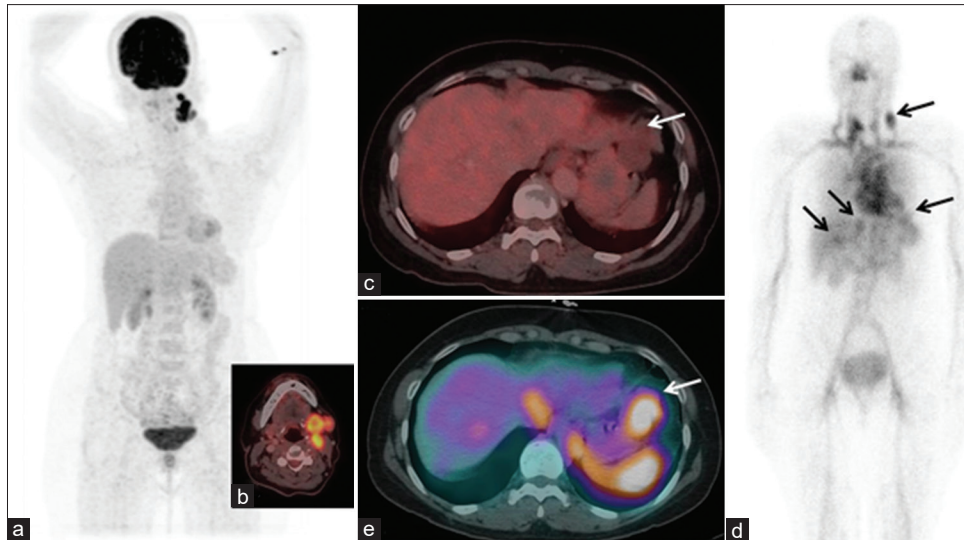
Staging F-18 fluorodeoxyglucose (FDG) PET/CT MIP image a) revealed hypermetabolic primary mass in left submandibular gland (black arrowhead) with (b) Inset axial hybrid image showing metastatic cervical lymph nodes (white arrowhead). c) Axial FDG PET CT images also revealed non avid mass lesion adjacent to the left hemi-diaphragm (white arrow). d) Whole body Tc-99m RBC scintigraphy was performed which showed multiple foci of increased tracer accumulation (black arrows in 1 hr image) in known sites. e) SPECT-CT images of the abdomen revealed Tc-99m RBC accumulation in the left subdiaphragmatic mass (white arrow) too
